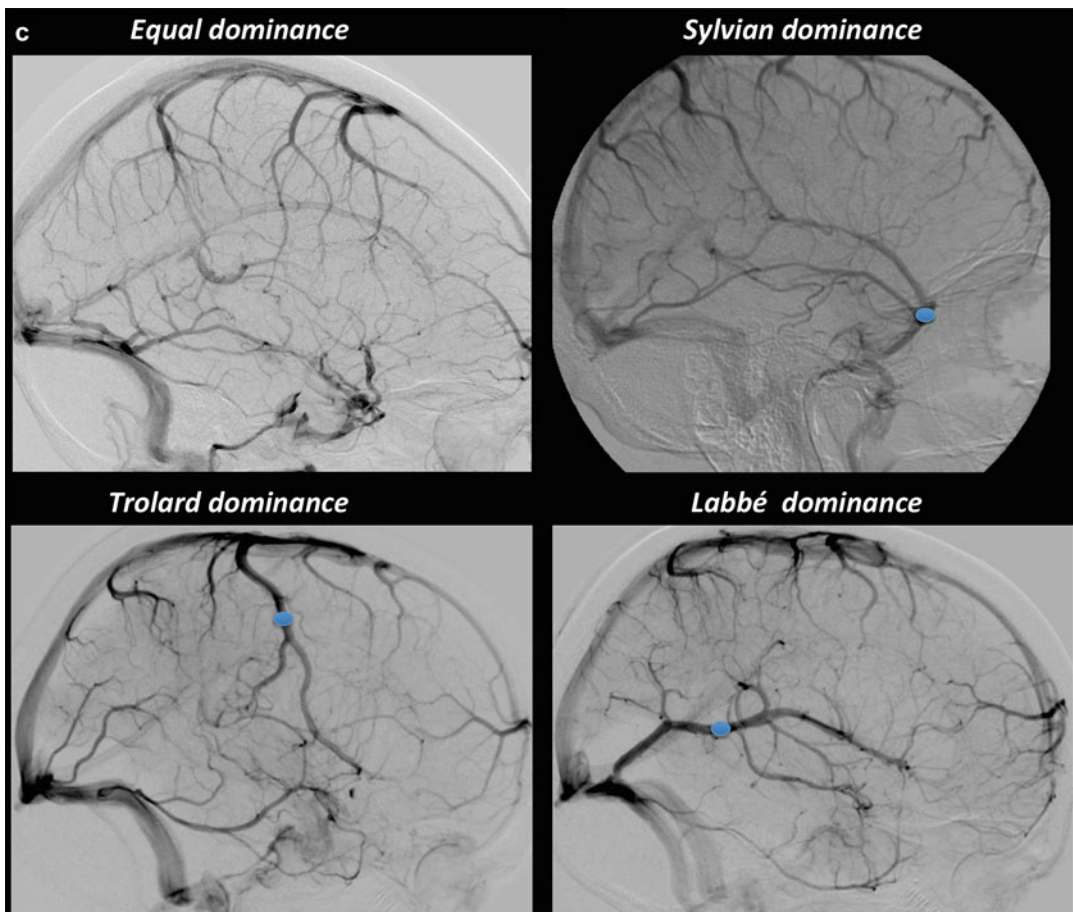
(a) DSA venous phase antero-posterior view DSA and axial CT demonstrate (congenital) left transverse and sigmoid sinuses hypoplasia. (b) Venous variants. DSA venous phase lateral view shows a superior sagittal sinus partial agenesis (upper image) in comparison to a complete
